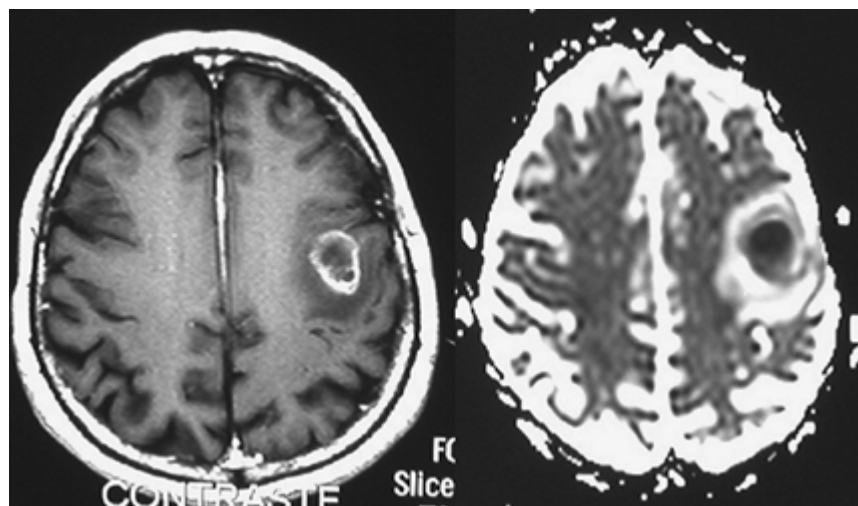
Gadolinium-enhanced, T1-weighted MRI (*left*) and apparent diffusion coefficient (ADC) map (*right*) of patient with brain abscess. Reduced ADC helps to differentiate abscesses from brain tumors (courtesy of Dr. Julio Lama, Guayaquil, Ecuador).
